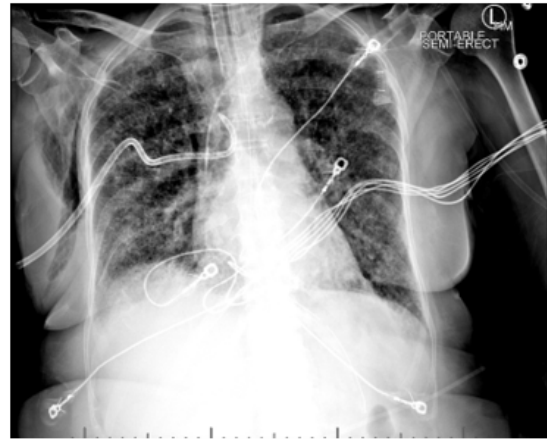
(Case 1): X-ray of chest post procedure, showing pigtail in the right main bronchus.
